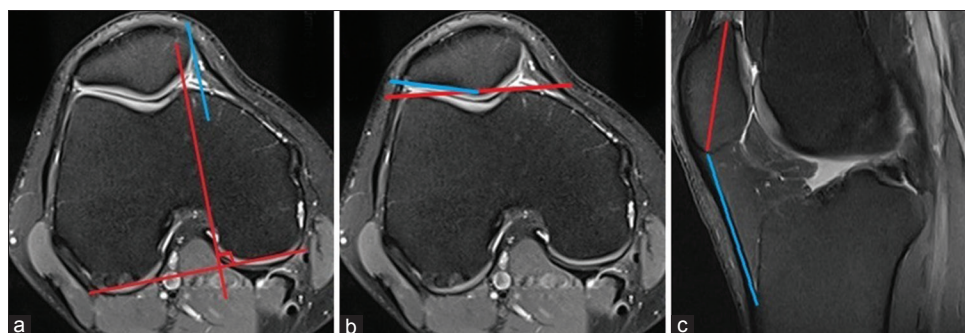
Axial (a and b), and sagittal (c) proton density weighted, fat-suppressed magnetic resonance imaging sections demonstrating the methods of determining patellofemoral alignment measurements. (a) Patellar translation. (b) Lateral patellofemoral angle. (c) Insall-Salvati ratio
